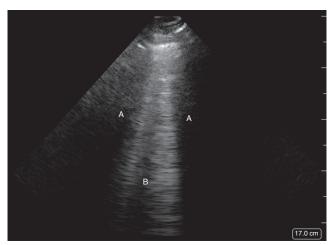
Ultrasound image of the lung showing (A) hypoechoic rib shadows and (B) "comet tailing" or B-lines caused by reverberation artifact in lung tissue. B-lines when present anteriorly to posteriorly from the pleural line to the bottom of the image represent pneumonia or consolidation. (Image courtesy of Jackie Shibata and Alan Chiem.)
